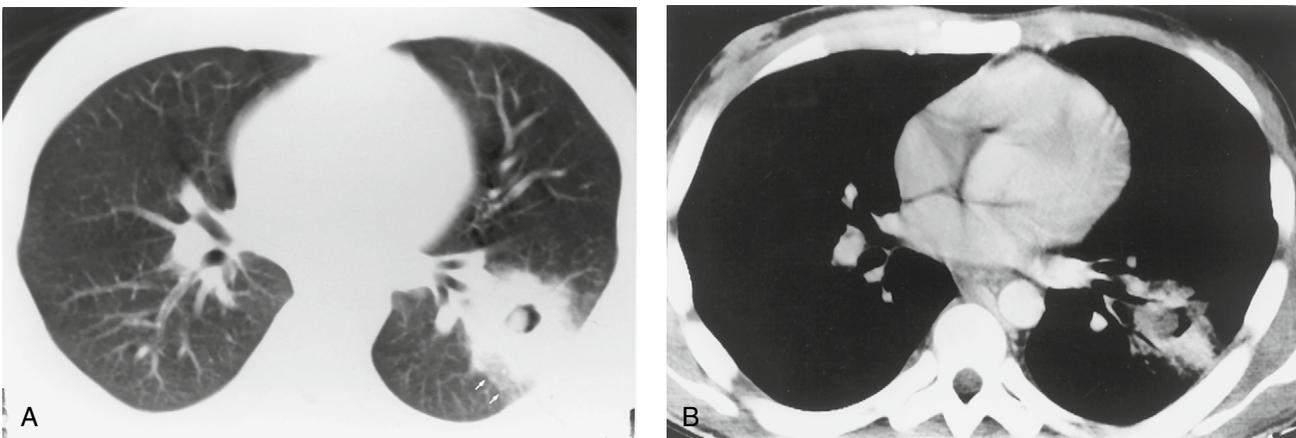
Invasive pulmonary aspergillosis in a 27-year-old man with end-stage acute myelogenous leukemia. (A) Chest CT image (lung window) shows an ill-defined opacity with central cavitation containing a small mass. Note the “halo” sign of ground-glass attenuation (arrows) adjacent to the posterior aspect of the opacity. (B) Chest CT image (soft tissue window) through the same opacity 2 weeks later demonstrates the cavitory opacity with an intracavitary low attenuation mass representing devitalized lung infiltrated with *Aspergillus* hyphae. IPA was diagnosed by bronchoscopy. The patient died despite amphotericin B therapy.
